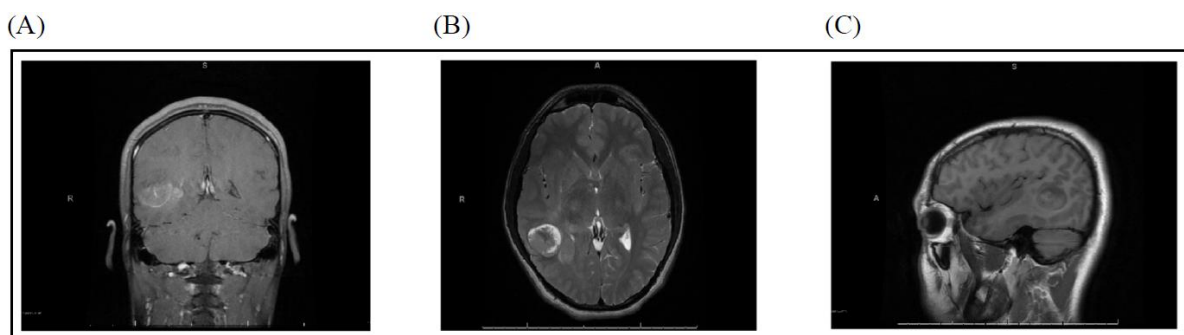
MRI Scans of GBM Bi-lobed Tumor in the Right Parietal Lobe
